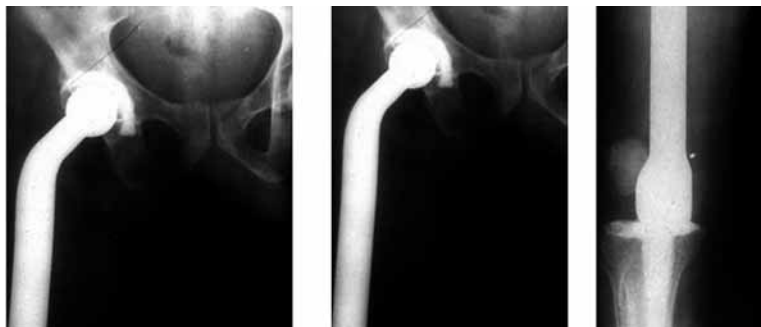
Post-operative radiographs of the femur of the patient after resection and reconstruction with total femoral prosthesis
